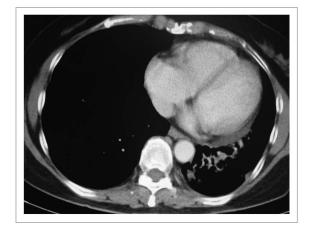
CT chest (month 18 from CIMAvax commencement), left lower lobe lesion 1.5 cm by 2.3 cm
